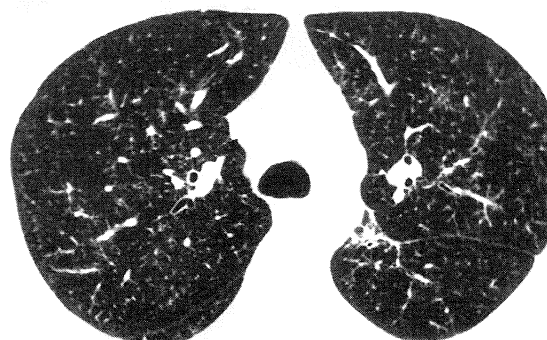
Corresponding 1mm HRCT scan displayed at parenchymal settings.
